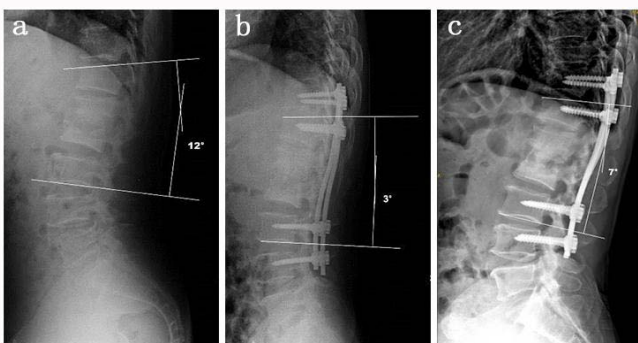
(a) A preoperative lateral X-Ray showing L1 and L2 vertebral damage. The kyphotic angle was 12°. (b) A postoperative lateral X-Ray showing anterior debridement, pressure release, autogenous bone grafting, and pedicle screw instrumentation. The kyphotic angle was corrected to 3°. (c) Four months after surgery, a lateral X-Ray showed good instrumentation and bone fusion. However, the kyphotic angle regressed to 7°.
